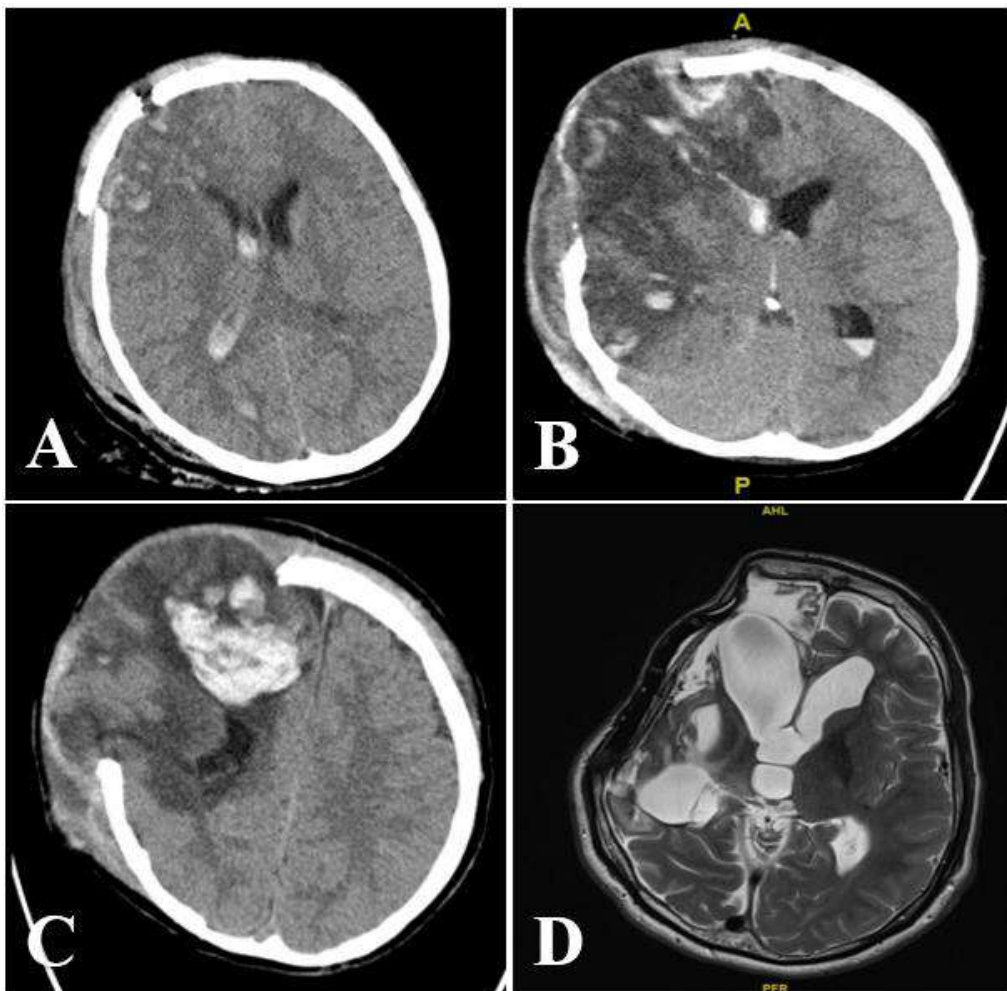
Serial CT scans of a 14-year-old boy, victim of severe head trauma, over 2 years.
